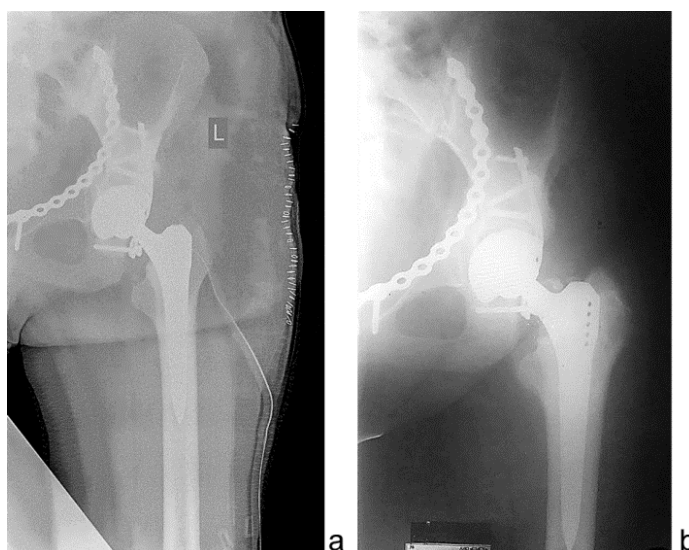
Postoperative radiographs of pelvis of the 32-year-old female patient T. showing total hip replacement performed at the second stage of treatment: (a), early postoperative period; (b), 6 months after THR
